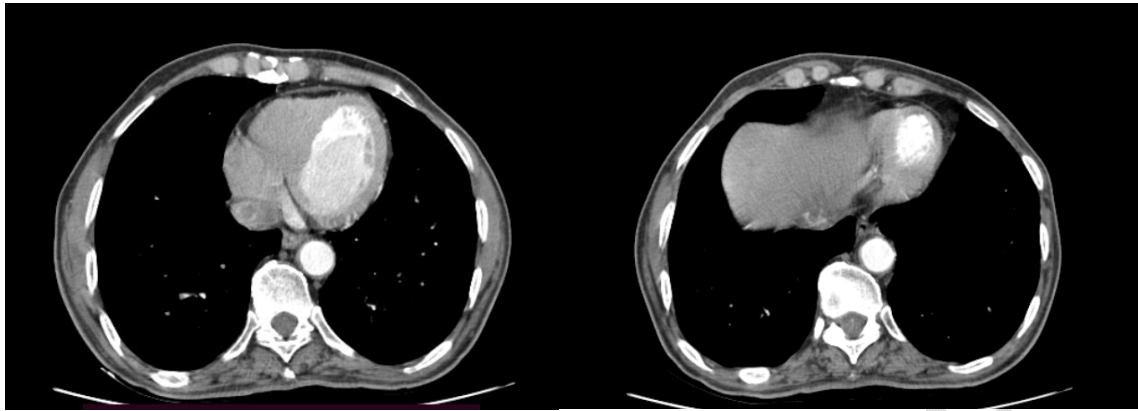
Transverse low thoracic CT scan showing circumferential wall thickening of the descending thoracic aorta.
